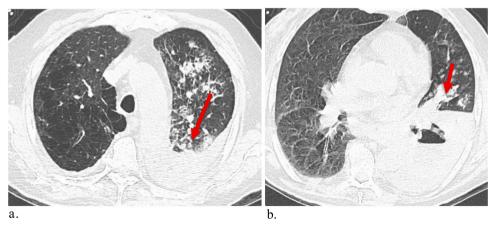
a and 1b: Axial CT scan of patient 1 showing necrotic lung mass.
